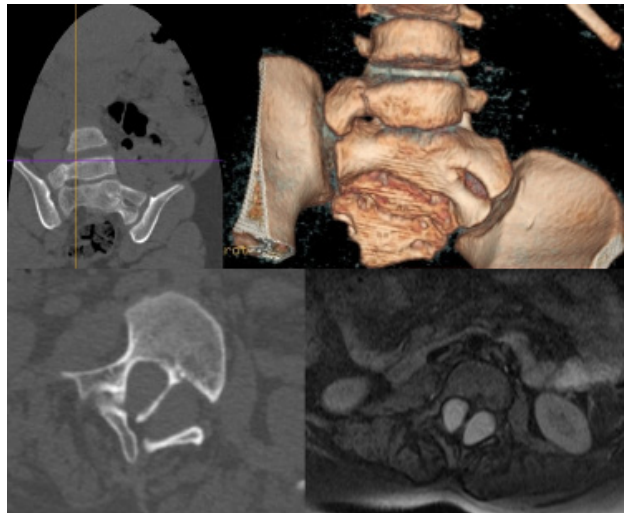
L5 mega-apophysis articulated to the sacral wing (up). Bony diastematomyelia evidenced on CT-scan and MRI.
